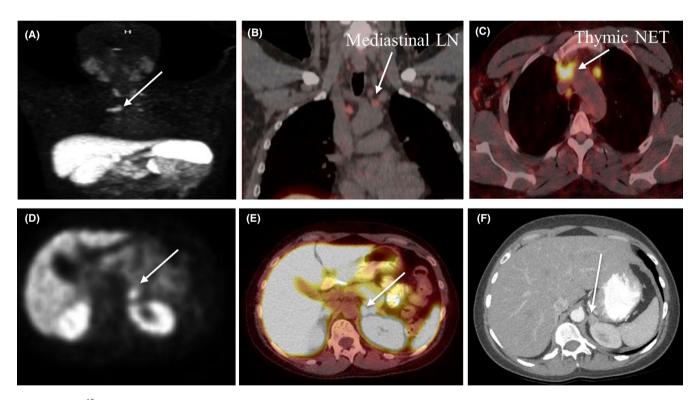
[⁶⁸Ga]-DOTATATE PET/CT demonstrated uptake in the thymus (A, C) and mediastinal lymph node (A, B, C). Pathology revealed high-grade thymic NET with mediastinal lymph node metastasis. [⁶⁸Ga]-DOTATATE PET/CT revealed focal uptake in the left adrenal gland (D, E). CT abdomen showed left adrenal thickening (F). Left adrenalectomy was performed, but pathology demonstrated adrenal cortex hyperplasia but no malignant tumour, and hypercortisolism did not resolve. NET, neuroendocrine tumour [Colour figure can be viewed at wileyonlinelibrary.com]
